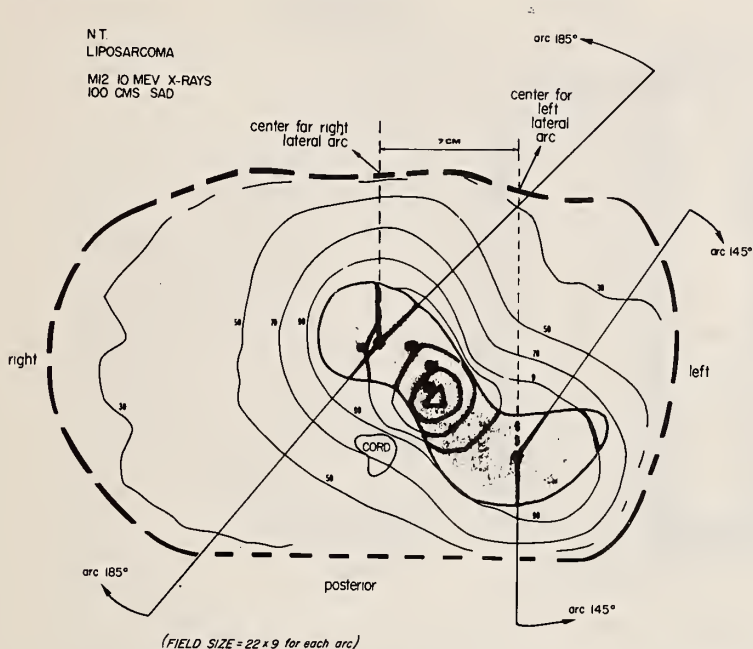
Patient treated for liposarcoma using a waving beam technique with 10 MV X-rays.
